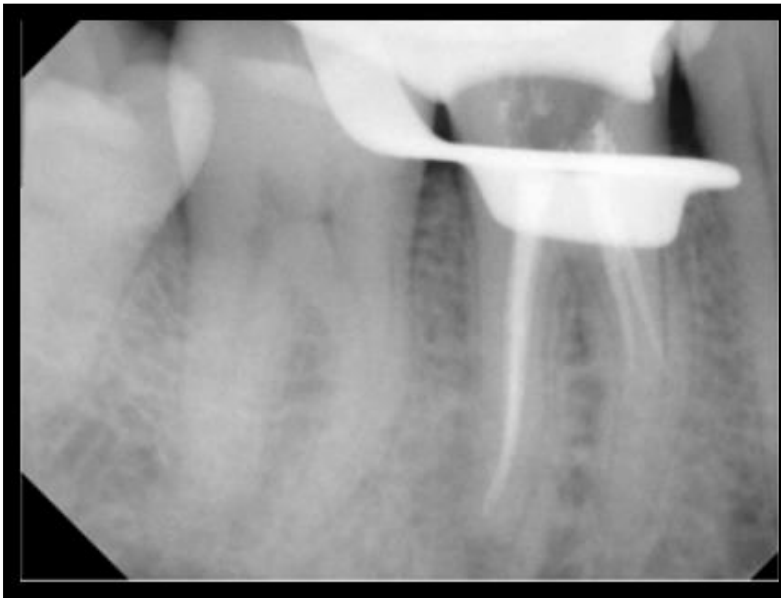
#36 Root Filling Extending Beyond the Radiographic Apex (Unacceptable)
